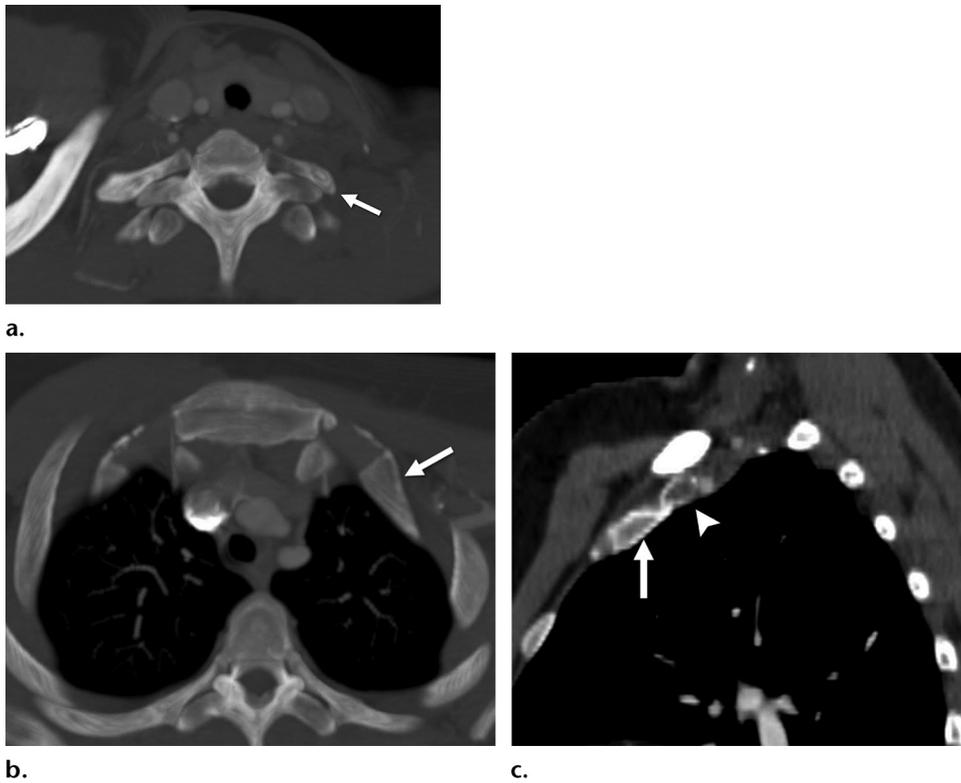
Remnant first rib in a patient who underwent left thoracic outlet decompression surgery but experienced multiple repeat thromboses of the left axillosubclavian vein. Ultimately, a stent was placed. (a, b) CT images at presentation to our institution show large posterior (arrow in a) and anterior (arrow in b) remnant portions of the left first rib. (c) Sagittal CT image with the left arm in abduction shows the anterior left first rib remnant (arrow) contacting the undersurface of the mildly compressed left subclavian vein stent (arrowhead). The patient underwent complete resection of the left anterior and posterior first rib remnants and did well without recurrent thrombosis. Identification of remnant portions of the resected first ribs is best performed with CT and may provide an explanation for recurrent symptoms.
